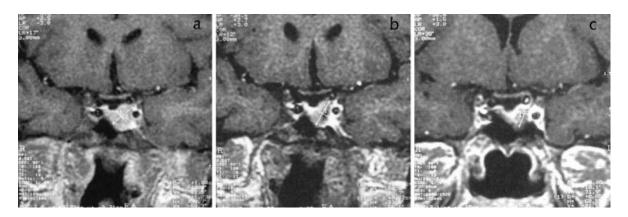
Tumour shrinkage during depot SMS-a therapy. Coronal plane, gadolinium-enhanced T1-weighted MRI scans of a macroadenoma (case 9) at the same level through the pituitary fossa before (a) and after 12 (b) and 24 (c) months of lanceotide SR therapy.
